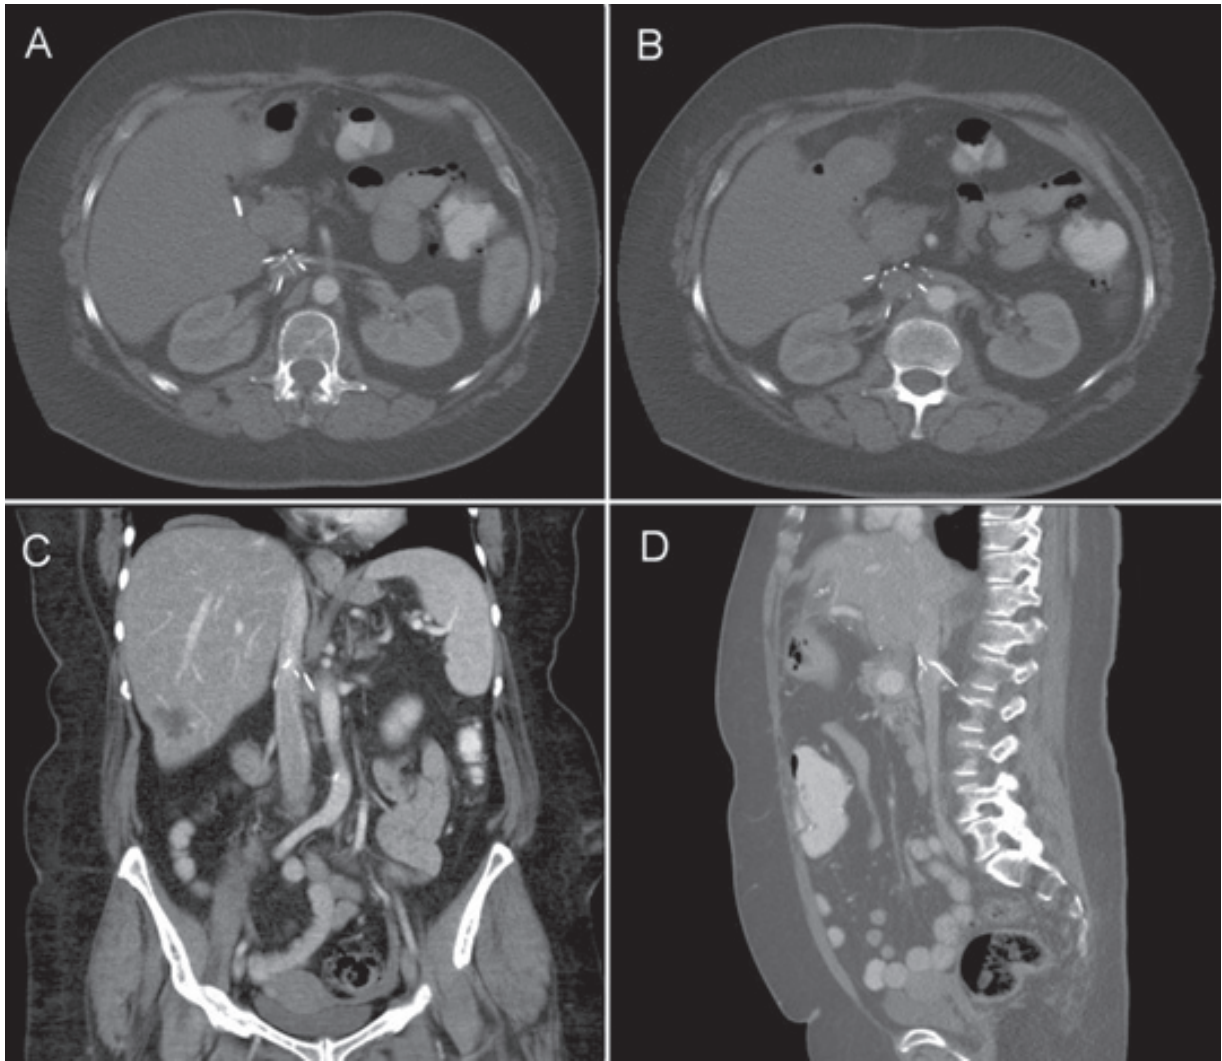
(A–D). Computed tomography scan showing perforation of vena cava by filter tines the close proximity of the tines to the aorta can be appreciated (B, C). Note the hook of the filter outside the lumen (D).
